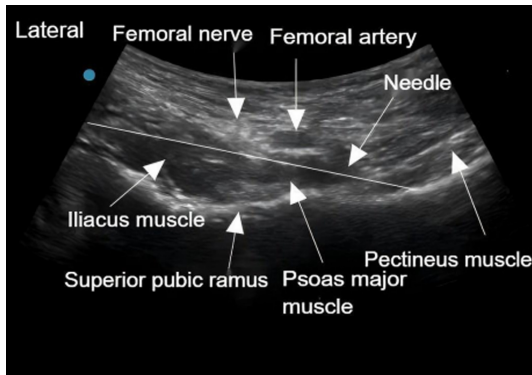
Suprapubic approach for obturator nerve block under ultrasound guidance.
